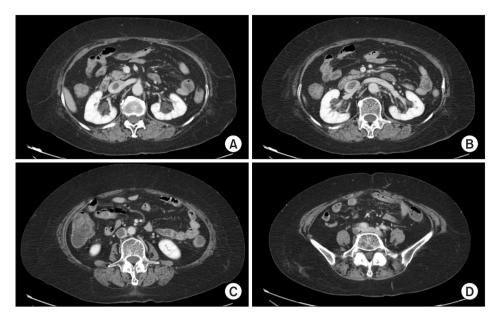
Computed tomography scan shows inferior vena cava (IVC) thrombosis at the level of the left renal vein (A), the right renal vein (B), the infrarenal IVC (C), and the right common iliac vein (D).
